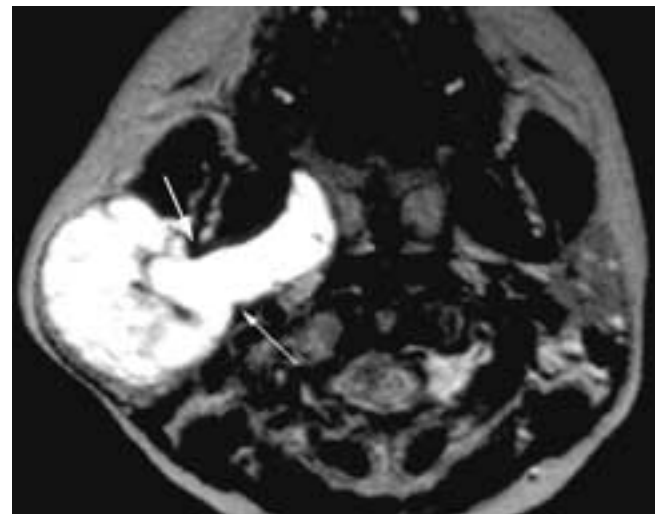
Axial T2-weighted MR image shows a high signal intensity lymphangioma filling the right parotid gland and extending through the stylomandibular tunnel into the prestyloid compartment of the parapharyngeal space. The thin arrow indicates the styloid process, and the thick arrow indicates the dorsal edge of the ramus of the mandible.
